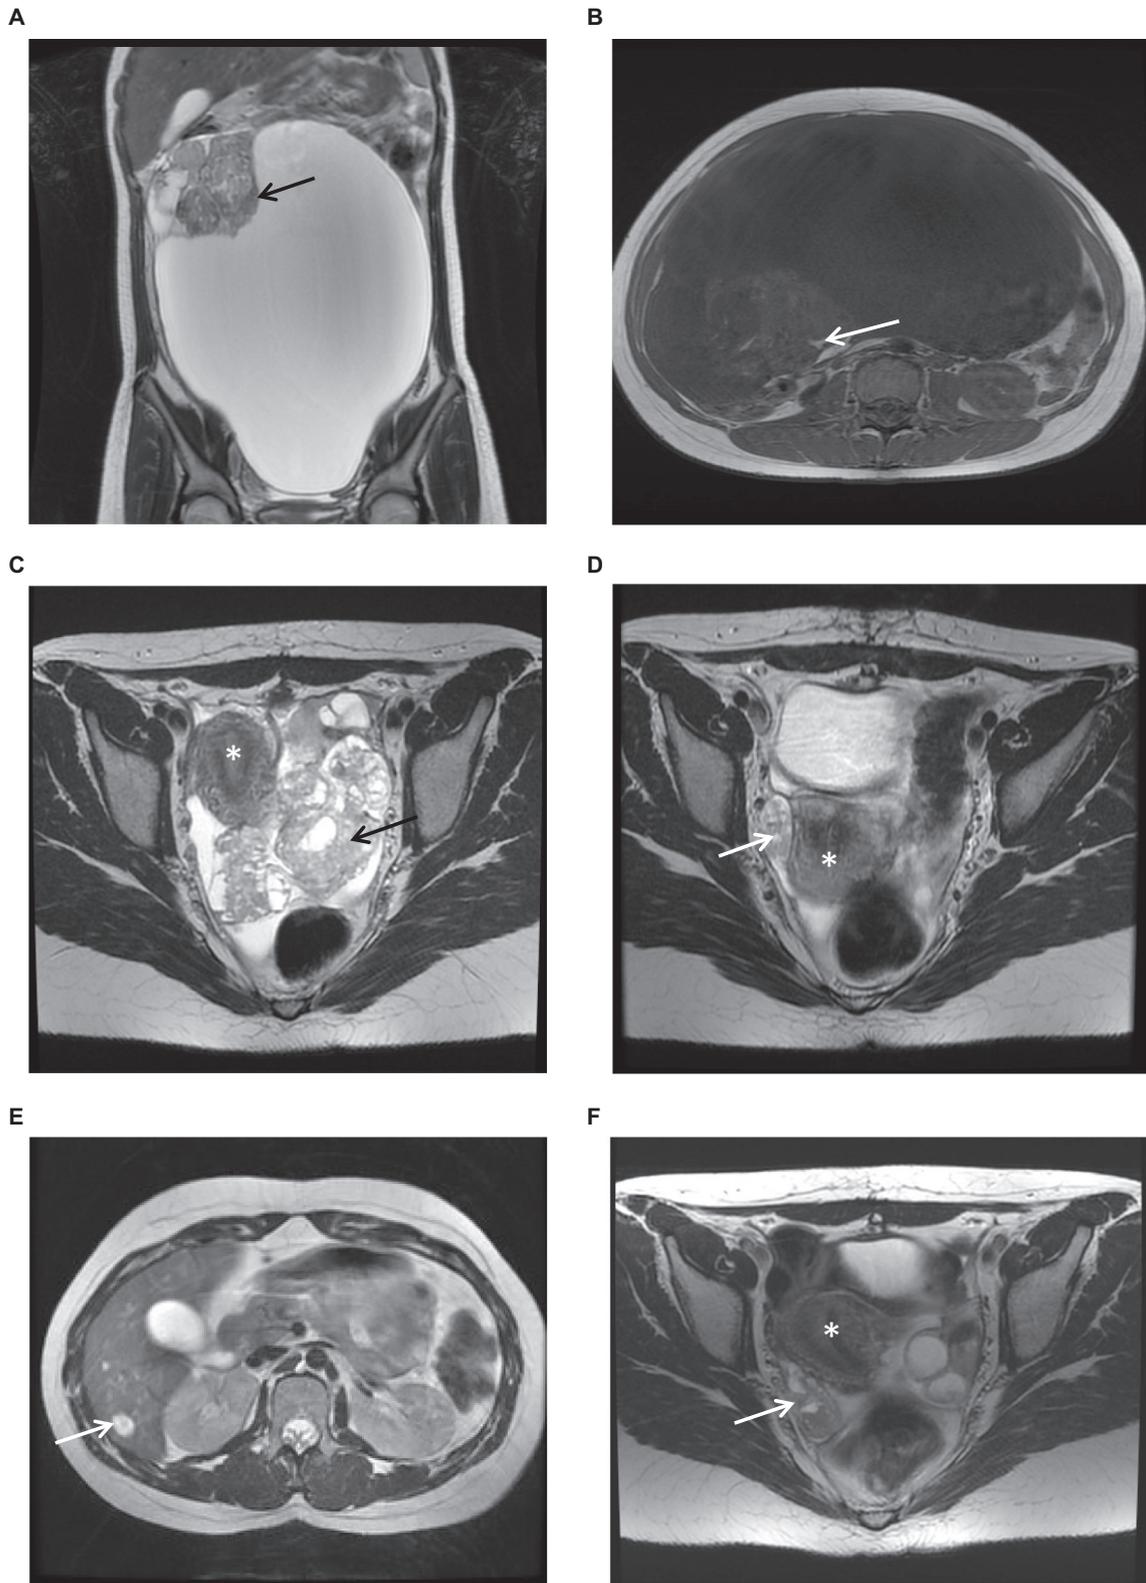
Radiological imaging for the ovarian immature teratoma case. A) Coronal T2 weighted MR image at diagnosis demonstrating a large cystic lesion arising from the right ovary occupying the entire abdomen and pelvis with complex solid contents (arrow); B) axial T1 weighted MR image demonstrating areas of high signal intensity (arrow) in keeping with small areas of fat; C) axial T2 weighted MR image five months following right salpingo-oophorectomy showing a complex mass (arrow) posterior to the uterus (*) consistent with first recurrent disease; D) axial T2 weighted MR image two months following surgical resection of pelvic recurrence demonstrating a complex mass in the right adnexa (arrow) adjacent to the uterus (*) in keeping with second recurrent disease; E) axial T2 weighted MR image at the same examination as in D) demonstrating a new liver lesion (arrow) confirming metastatic disease; and F) Axial T2 weighted MR image of the pelvis following two cycles of chemotherapy revealing an increase in size of the lesion (arrow) posterior to the uterus (*).
